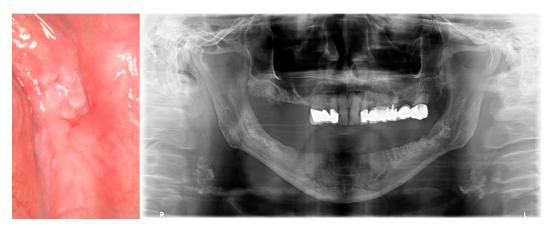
Clinical view #37 and 38 teeth area and a panoramix X-ray at 12-month postoperative control showing good healing
